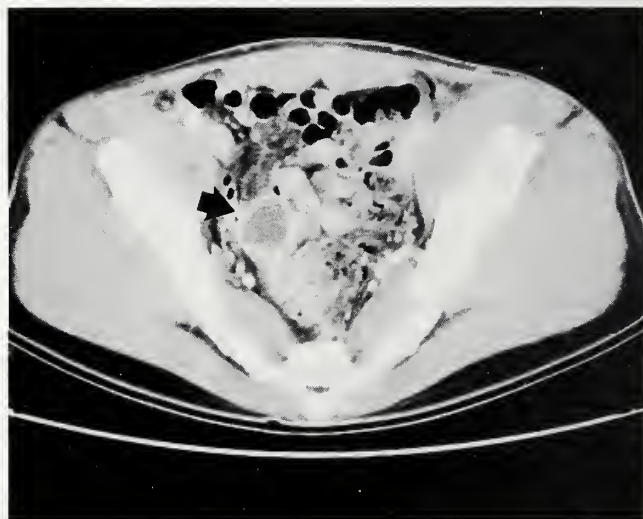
Axial CT image of mid-pelvis, showing ovoid fluid-filled mass.
